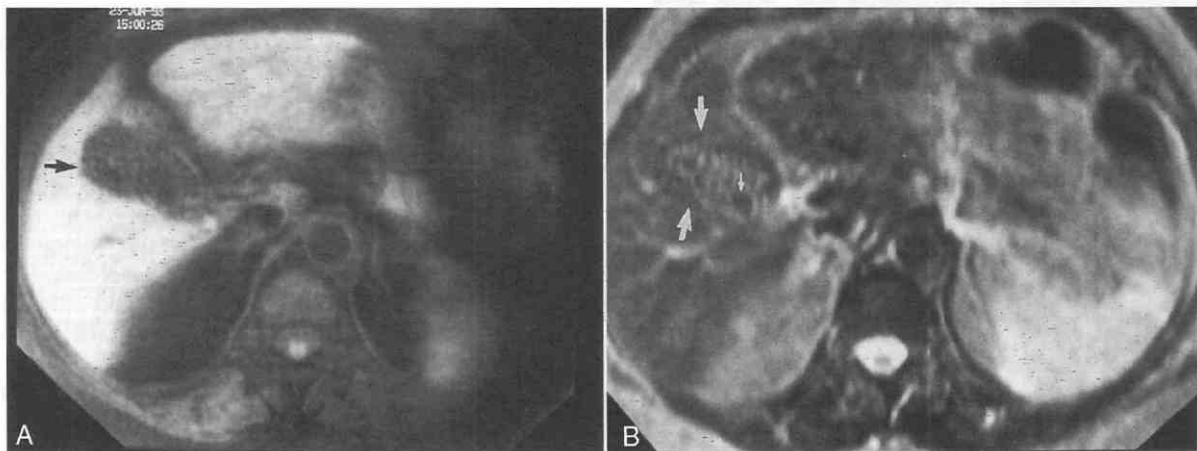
Gallstones. *A*, Fat-suppression T1-weighted image showing gallbladder (*arrow*) with multiple tiny stones presenting as signal voids. *B*, T2-weighted image of same patient showing gallbladder (*large arrows*) and gallstones (*small arrow*).
